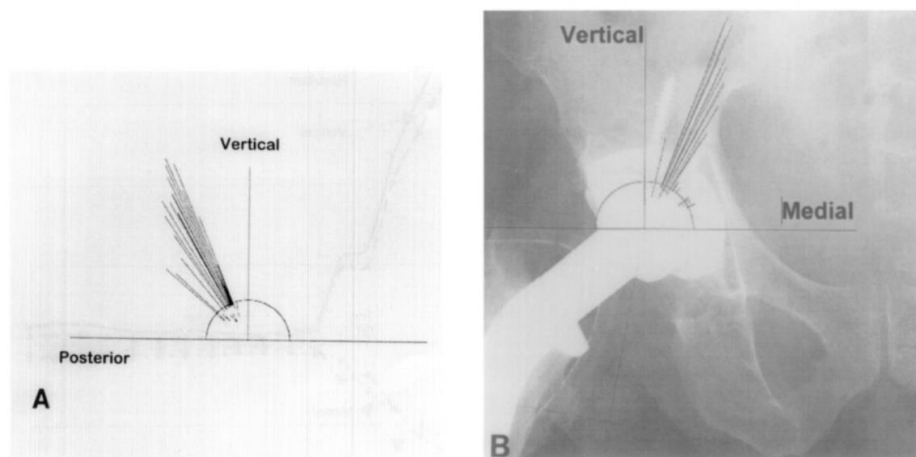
Directions of acetabular contact forces during the gait cycle. The data has been superimposed onto an X-ray of a patient with a telemetered implant to demonstrate the contact force directions (236).
